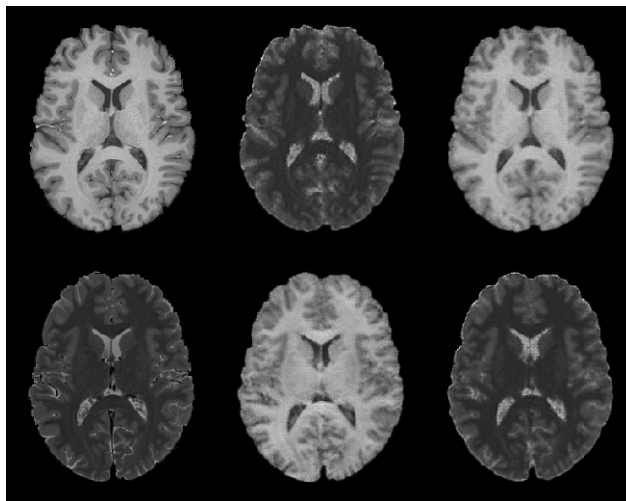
Image-to-image translation between T_1 - and T_2 -weighted MRI images using CycleGAN, which simultaneously learns to translate both domains into each other. Top: T_1 to T_2 translation. Bottom: T_2 to T_1 translation. Left: original image. Center: translated image. Right: cycle consistency image, obtained by translating the central image back to its original domain.
